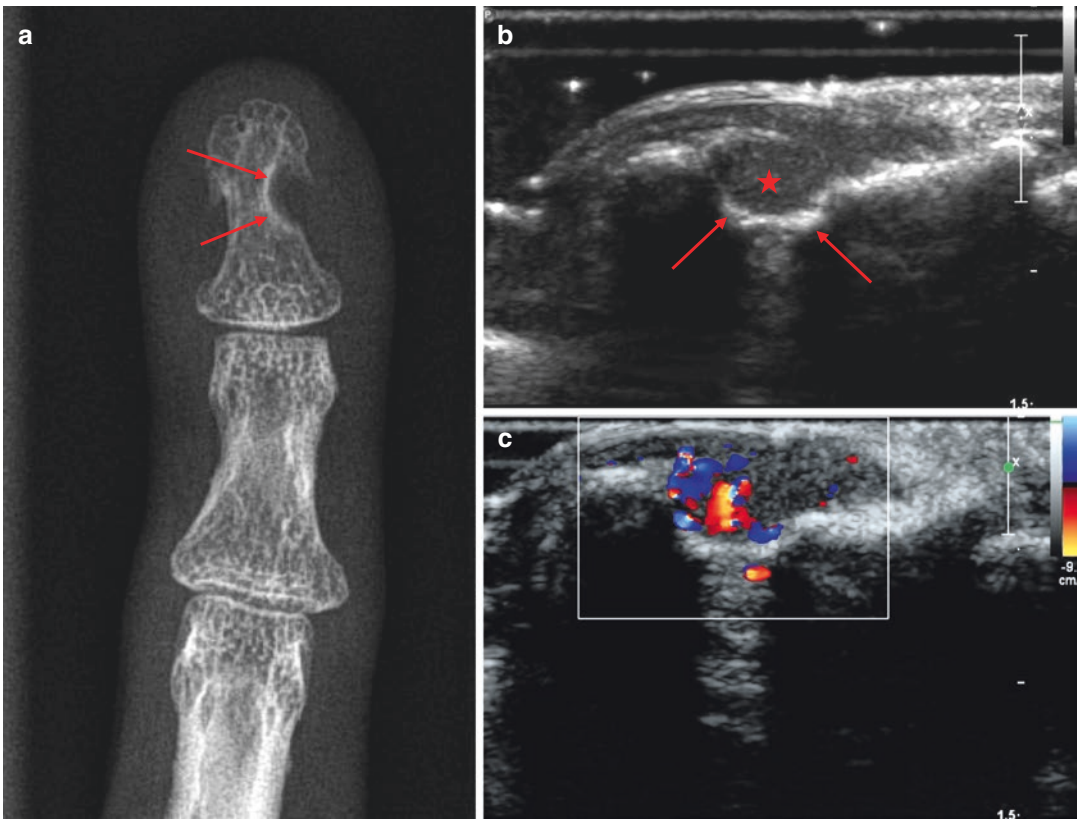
Glomus tumor. Radiograph (a) shows extrinsic scalloping (*thin arrows*) of the distal phalanx and a sclerotic rim. Longitudinal US (b) reveals a circumscribed homogenous hypoechoic nodule (*star*) in the subungual
